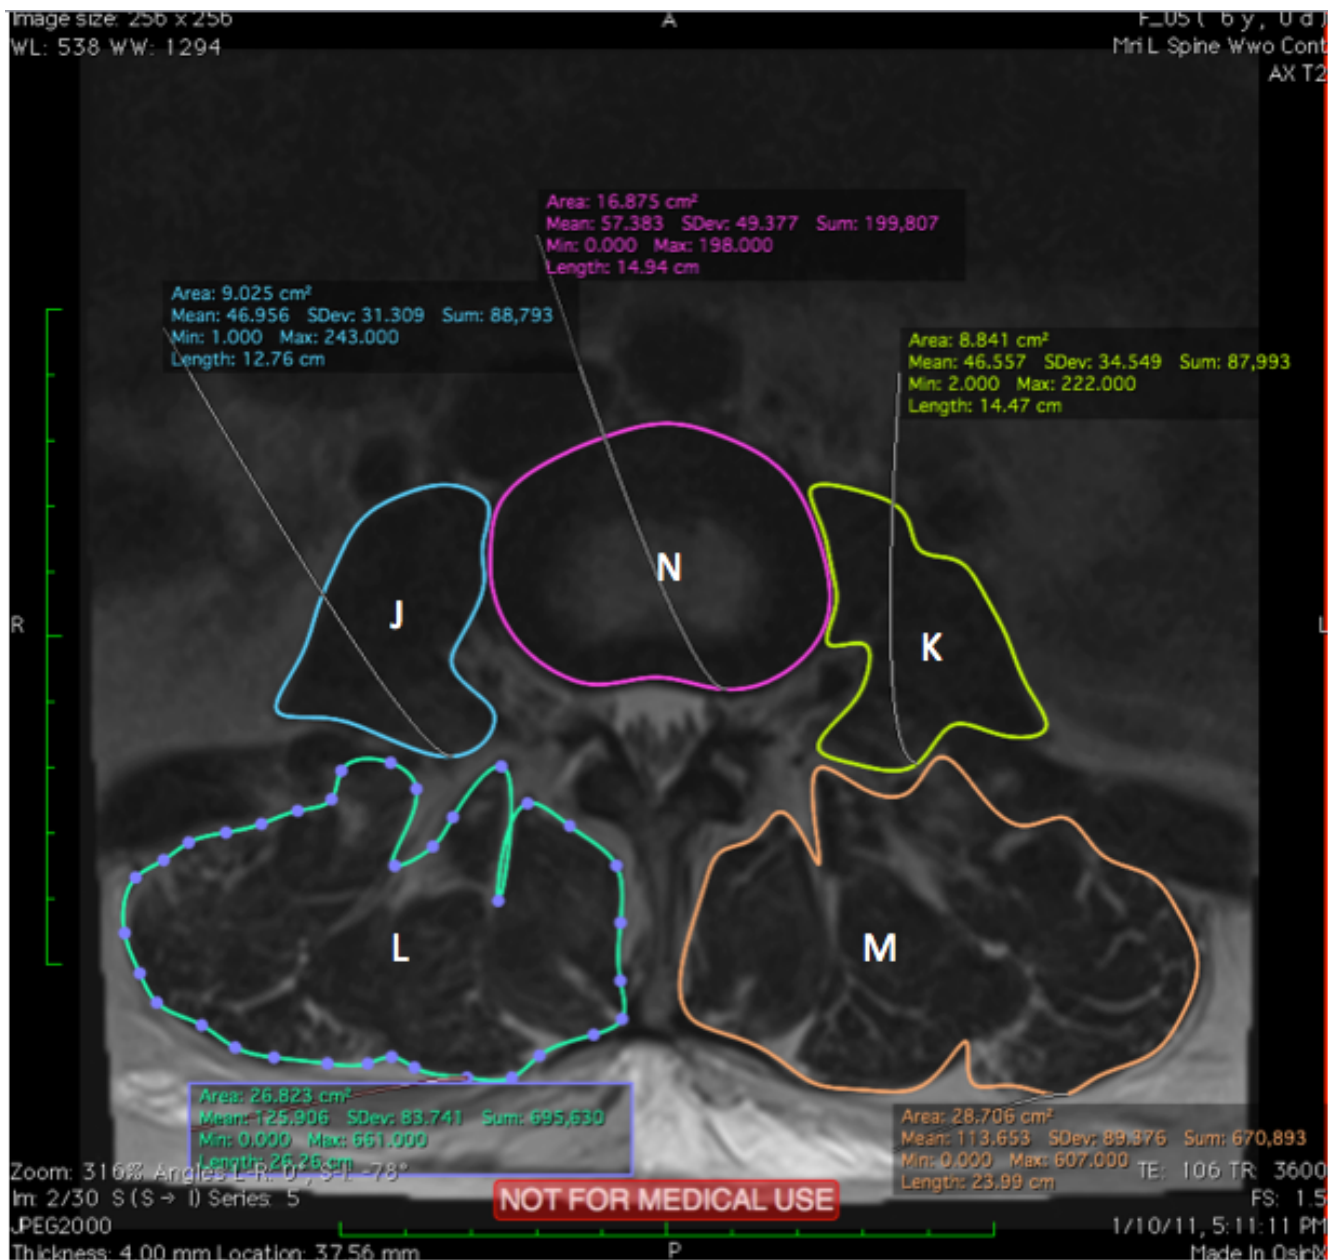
Axial MRI scan with measurements of J (Cross-sectional area of Psoas Right), K (Cross-sectional area of Psoas Left), L (Cross-sectional area of Erector Spinae Left), M (Cross-sectional area of Erector Spinae Right) and N (Disc Size)
